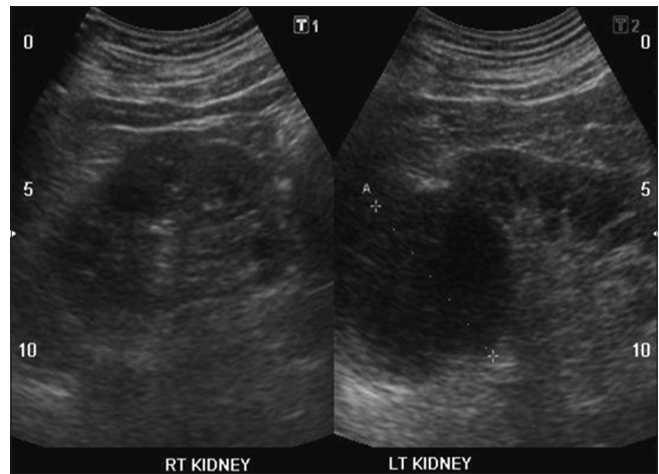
Ultrasonography of the kidney, ureter, and bladder showing a 6 cm × 7 cm simple cortical cyst at upper pole of left kidney
